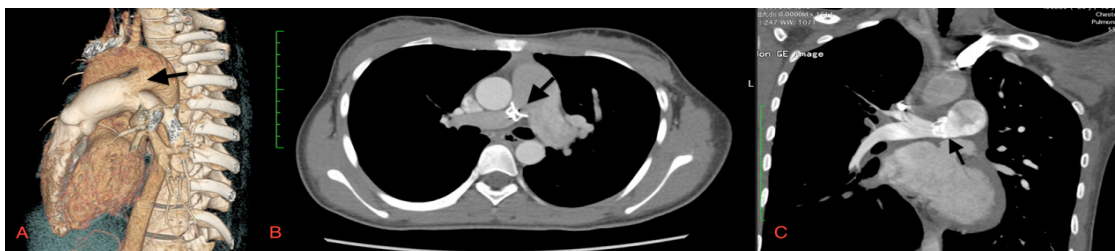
(A) Three-dimensional images showing the PDA. (B) Cross section CT image showing the displaced occluder. (C) Longitudinal section CT image showing the displaced occluder and fewer pulmonary arteries in right lung field.
